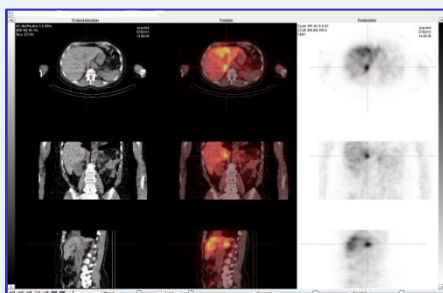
SPECT-CT scan showing localization to the right adrenal gland
